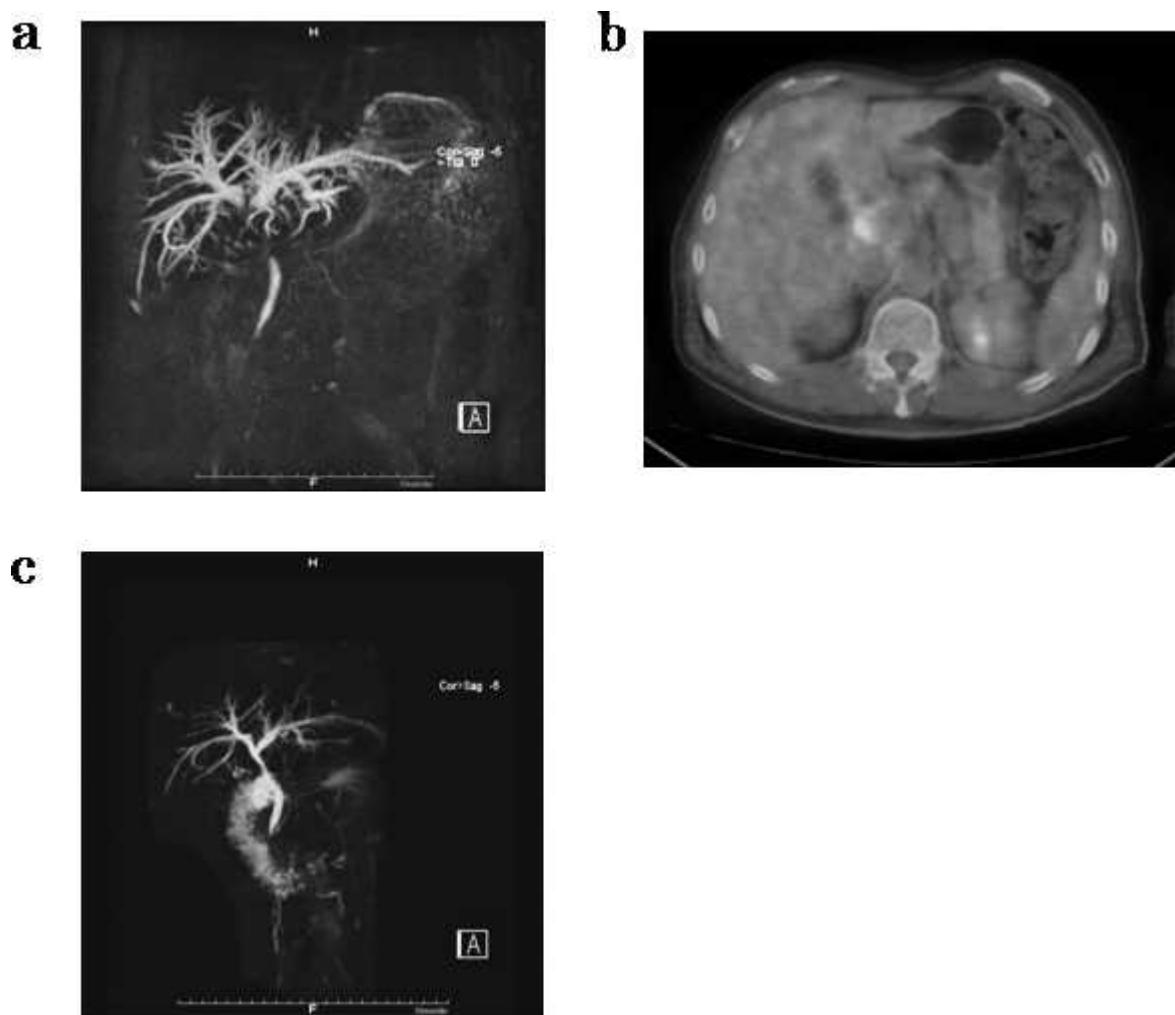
(a) Cholangiography with MRCP shows bile duct stenosis before the steroid therapy. (b) PET/CT revealed accumulation in the hilar bile duct, and SUVmax was 5.3. (c) MRCP showed no stenosis after the therapy.
